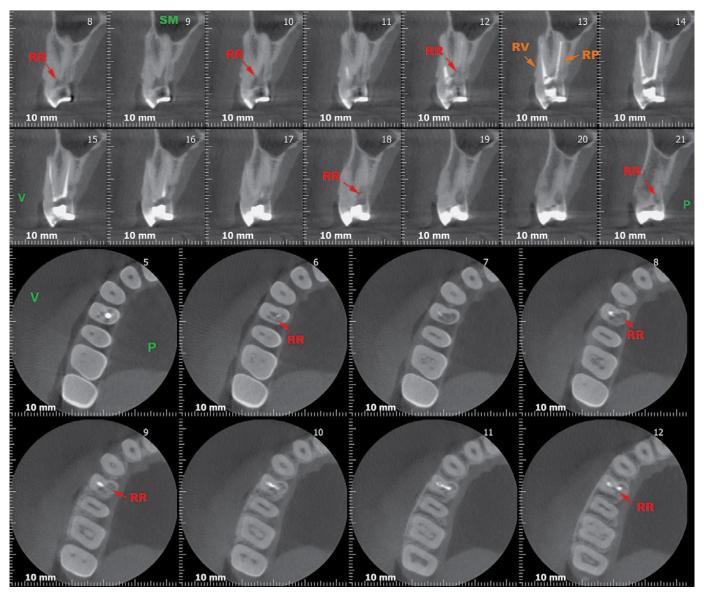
CBCT scan after dressing with calcium hydroxide (Dec/2013). In sagittal and axial slices, root resorption is observed in the coronal cervical third at the level of the pulp chamber and the cervical third at PR of tooth #14, extending in distal and palatal direction. No disruption of the distal and palatal tooth walls was observed, despite their obvious thinness.
